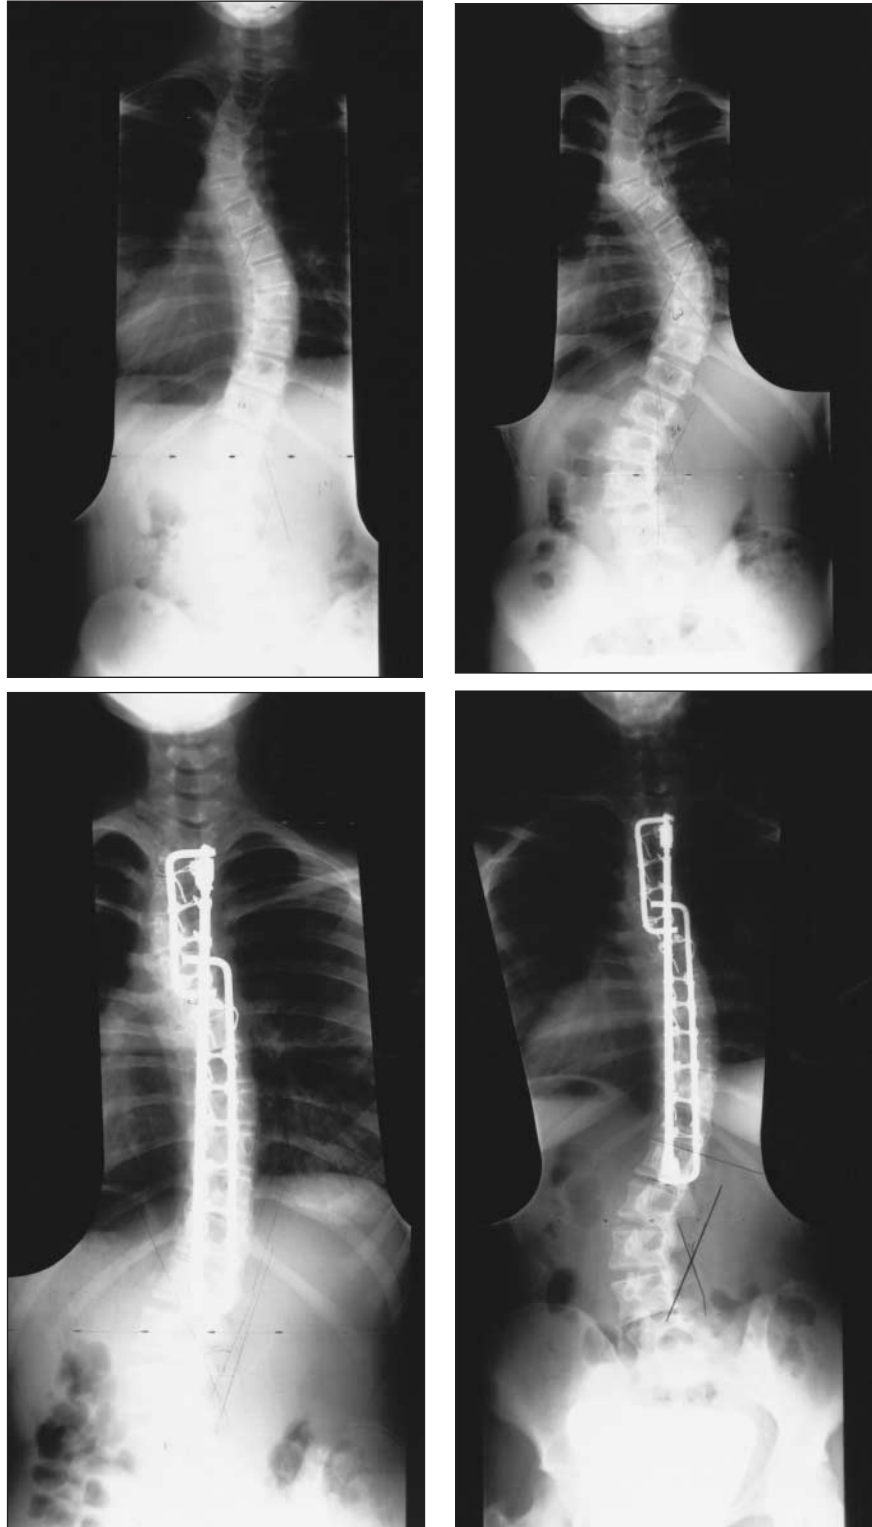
Case 4. The radiograph of this child's spine at the age of 11 years 2 months demonstrates an upper thoracic curve, convex left, of 44° , a middle thoracic curve, convex right, of 45° and a lumbar curve, convex left, of 34° (top left). A radiograph 4 months preoperatively indicates significant progression of the upper and middle curves to 45° and 62° , respectively, with no progression of the lower curve (top right). A radiograph 3 months postoperatively demonstrates good correction and stable fixation (bottom left). Six years postoperatively (child's age 17 yr 11 mo), there is curve stabilization without significant progression (bottom right).
